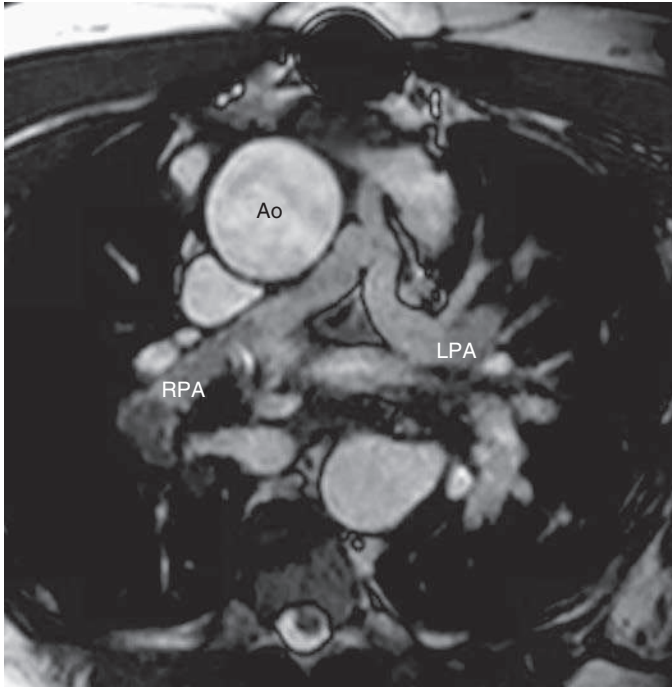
Axial magnetic resonance imaging showing a small interposition graft with a main pulmonary artery (MPA) remnant, and a dilated ascending aorta. Ao, Aortic arch; LPA, left pulmonary artery; RPA, right pulmonary artery.
